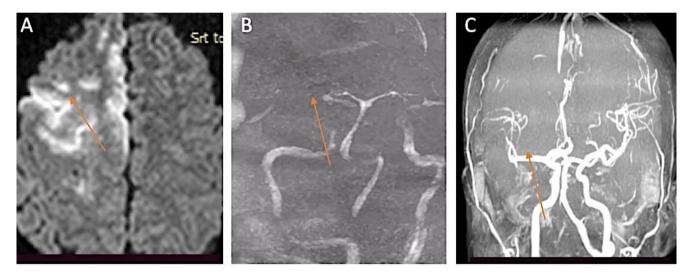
Images of young AIS patient: Brain magnetic resonance imaging diffusion-weighted imaging shows bright signal in the left middle cerebral artery territory (A) (red arrow); magnetic resonance angiography at admission shows non visualization of M1 (B) (red arrow); magnetic resonance angiography at 48 h post thrombolysis shows recanalization (C) (red arrow).
